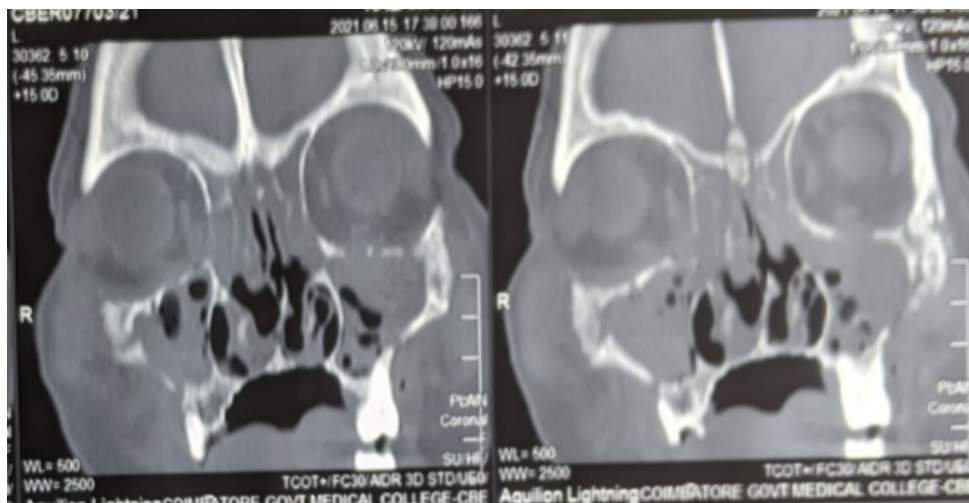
Computed Tomography images showing ROCM involvement
